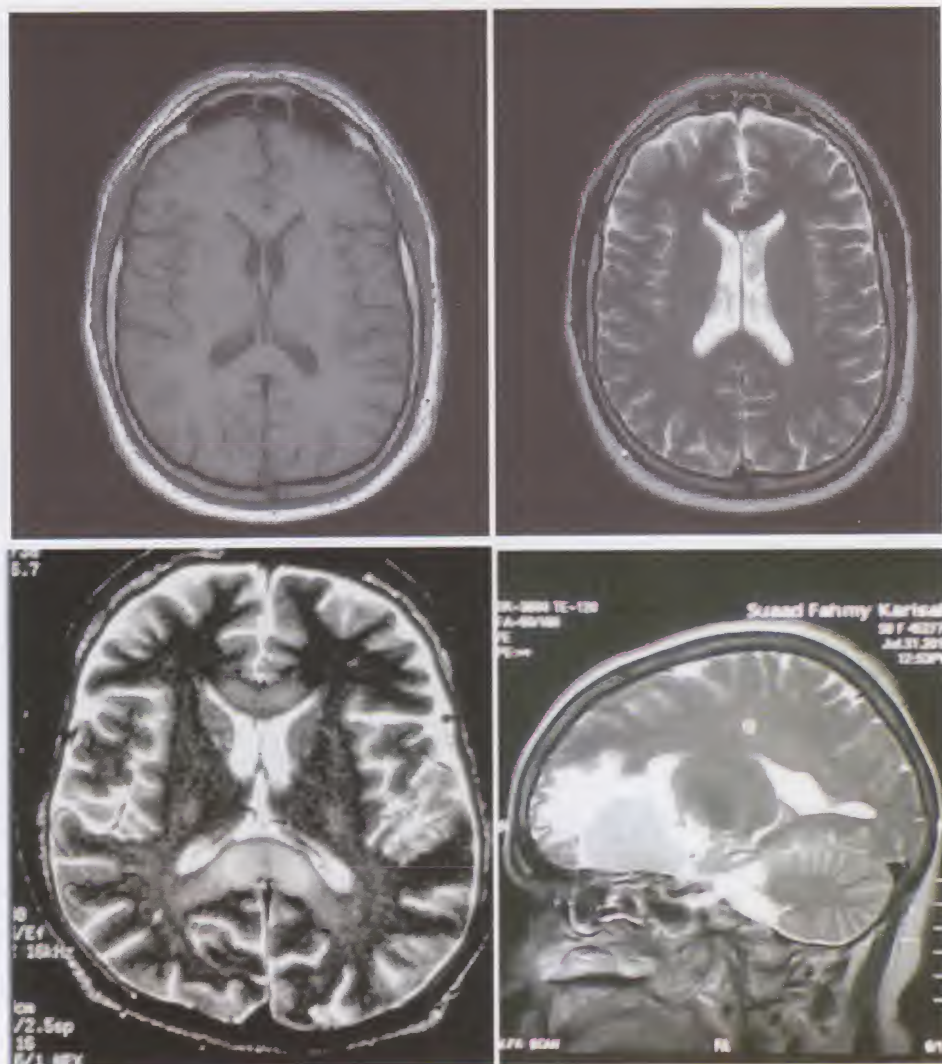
MRI brain. Normal T1 weighted axial brain MRI (the left upper image), normal T2 weighted axial brain MRI on which CSF gives a bright signal (the right upper image), generalized brain edema (the left lower image) and brain edema around a brain tumor (the right lower image).
